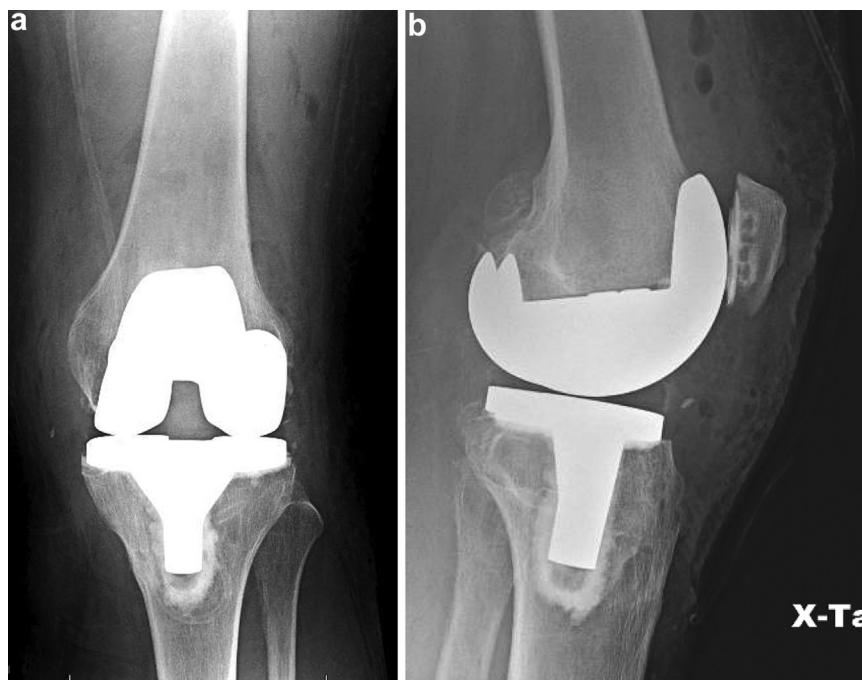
(a) Postoperative AP demonstrates well aligned TKA components. (b) Postoperative lateral radiograph with well fixed and aligned components.
